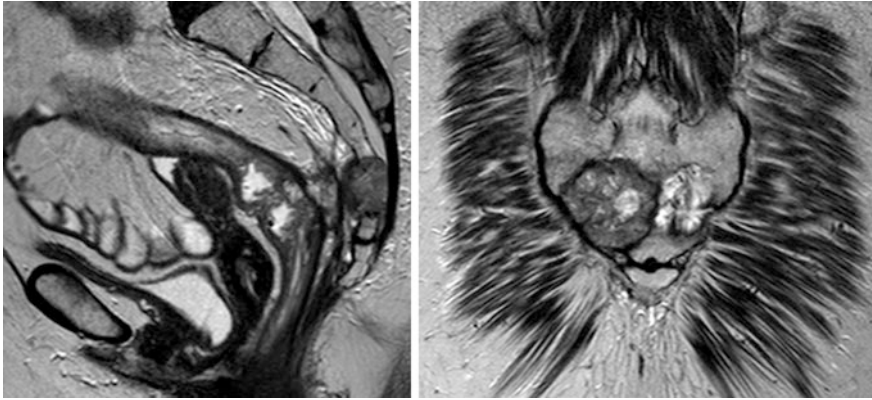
Accurate delineation of structures and tumour with the help of MRI
